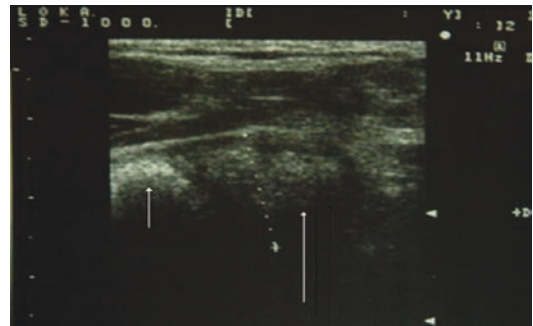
Longitudinal ultrasound image showing an indirect inguinal hernia (white arrow) taken in the resting position. Short white arrow indicates femoral head. With permission from Alam A, Nice C, Uberoi R. The accuracy of ultrasound in the diagnosis of clinically occult groin hernias in adults. *Eur Radiol*. 2005;15(12):2457–2461
